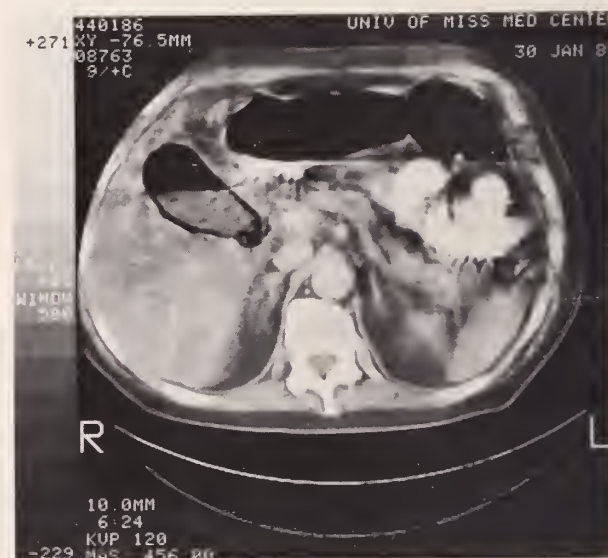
CT scan demonstrates a large gas-fluid level within gallbladder lumen. Gas is also seen within the wall of the gallbladder and extending into the proximal cystic duct.
